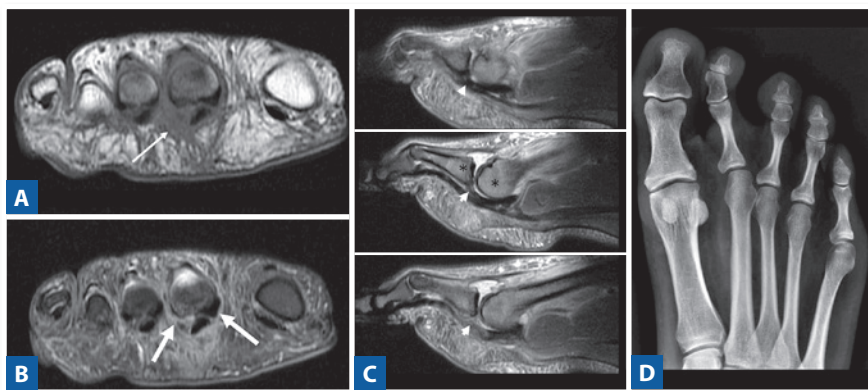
Anatomy of the plantar plate. MRI images. (A) Sagittal image, T2-weighted fat-saturated sequence. (B, C) Coronal images, T2-weighted fat-saturated sequences with. Plantar plate (arrowhead). Central groove in the sagittal and axial images, which should not be confused with tearing (thin arrow). Lateral insertional plantar complex, where the injury frequently starts, name of the term phalangeal apparatus adapted by the authors (thick arrow).
